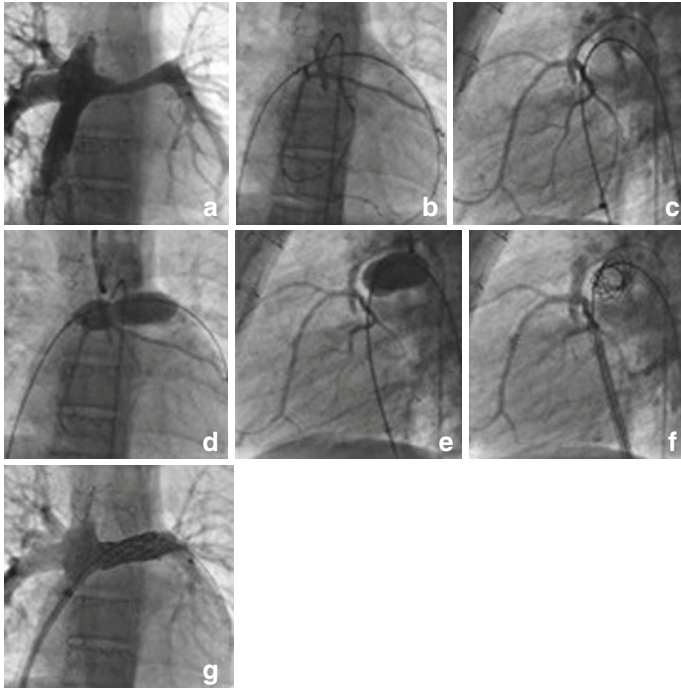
Stent implantation into left pulmonary artery after stage III Norwood procedure in a 17-year-old boy (a). MRI scanning raised concerns of proximity of both the left main bronchus and native aorta to the stenosed segment confirmed on angiography in AP and lateral projections with the guide wire in position (b, c). Trial balloon inflation to the stent diameter was performed with simultaneous native aorta angiography and bronchoscopy without compromising either structure (d, e). A Cheatham Platinum stent was implanted (f, g)
